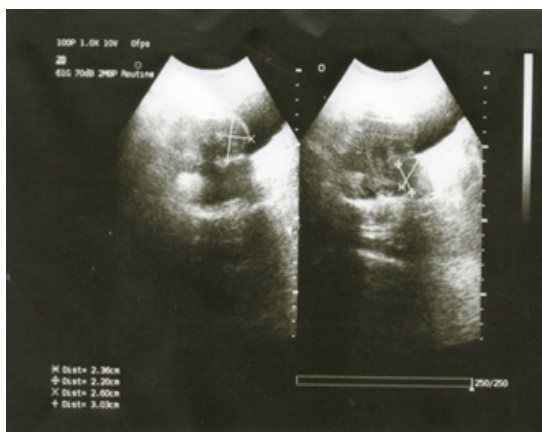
Ultrasound image showing two uterine fibroid masses. The largest fibroid was 3 x 2.6 cm and the other one measured 2.2 x 2.3 cm at its greater dimensions.
